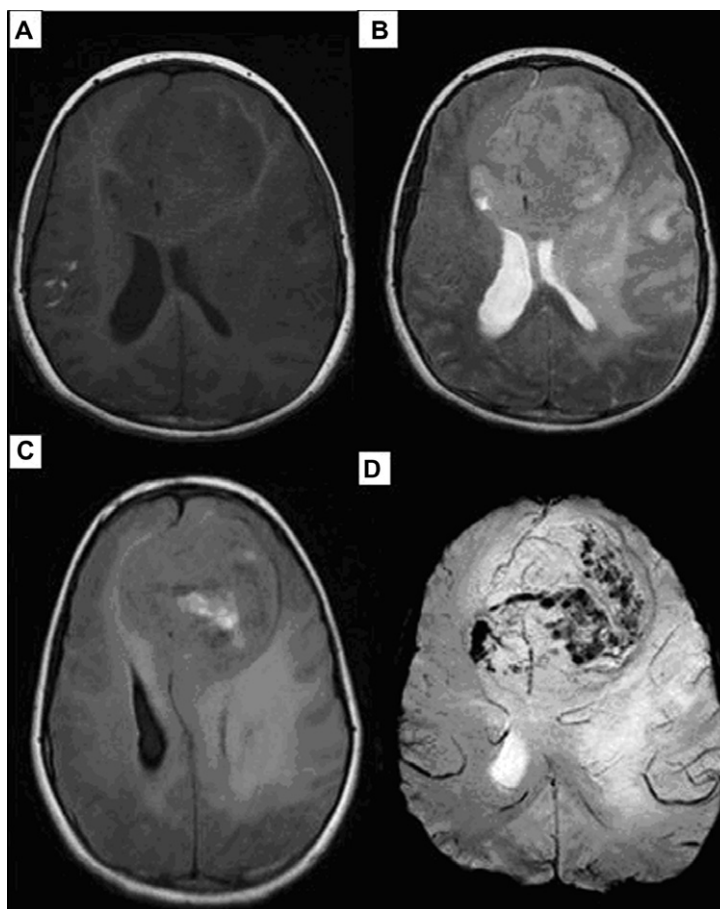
Twelve year old male patient presenting with disturbed sensorium. T1 (A), T2 (B) and FLAIR (C) images show sizable glioma with suspected hemorrhagic foci on T1, SWI (D) confirm and reveal the more extensive hemorrhagic elements as well as high internal vascularity denoting high grade glioma.
